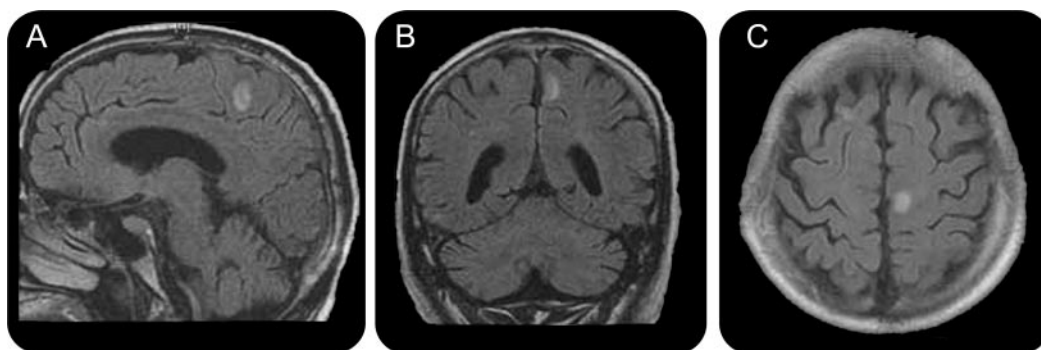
Fluid-attenuated inversion recovery sequences of brain MRI
